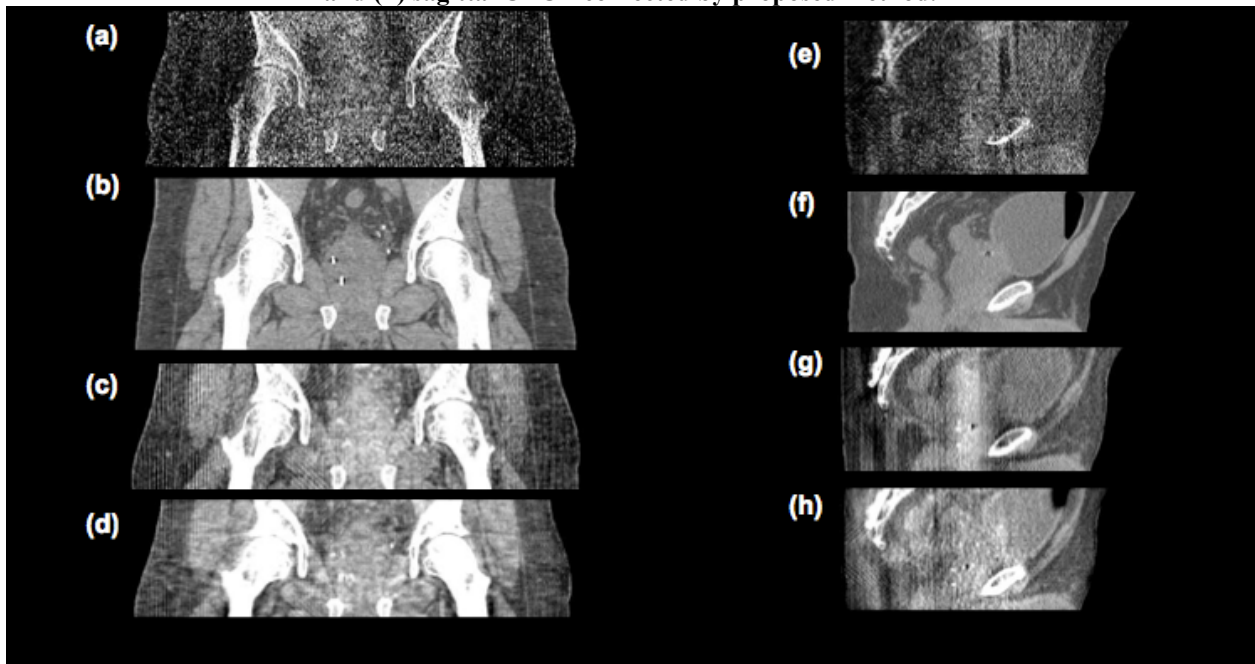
Second example of successful shading corrected CBCT images (Patient B) in coronal and sagittal views.
